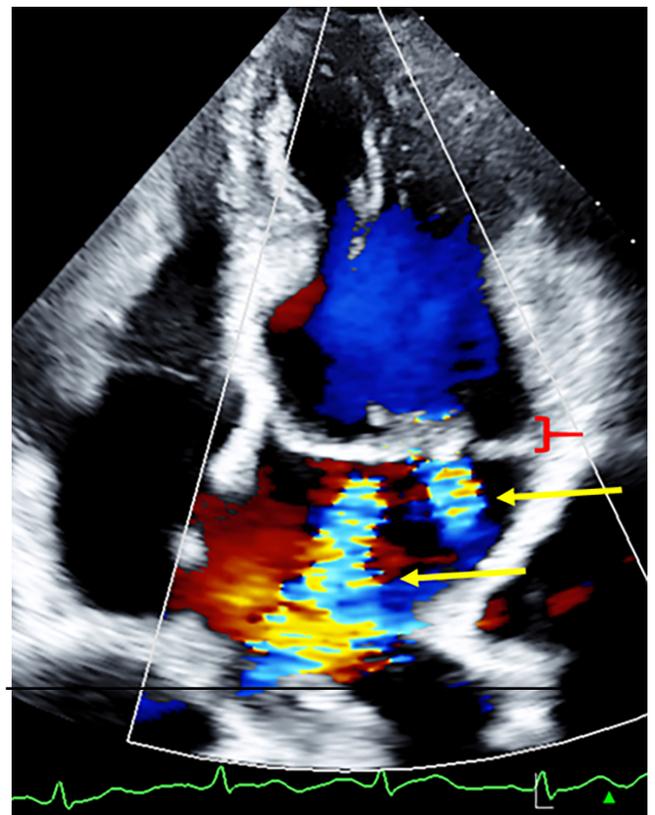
Transthoracic echocardiography demonstrating mitral annular disjunction (red bracket) associated with severe mitral regurgitation (yellow arrows) in Case 3.
